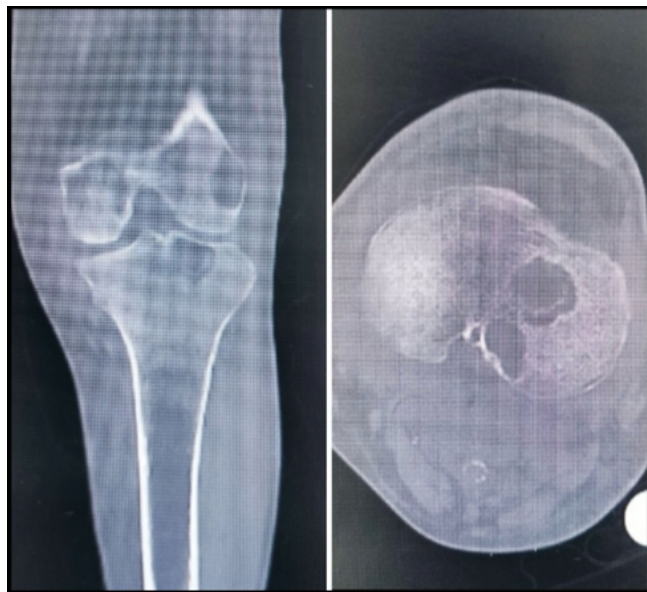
Magnetic resonance imaging of the left knee showing a round cystic lesion with thin sclerotic margins in the lateral femoral condyle, lateral tibial plateau, and intercondylar eminence communicating with the joint. Moderate joint effusion is appreciated.
